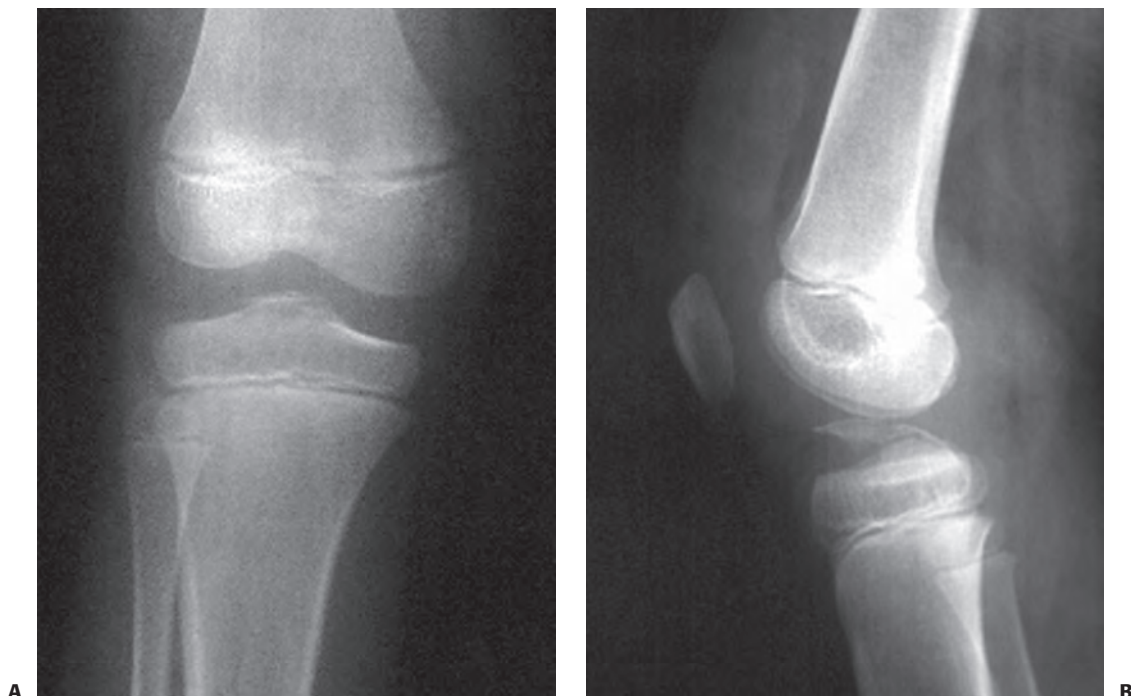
Type III tibial spine fracture in an 11-year-old male child treated with arthroscopic reduction and 3.5-mm cannulated screw fixation. Preoperative AP (A) and lateral (B) radiographs. Postoperative AP (C) and lateral (D) radiographs.
